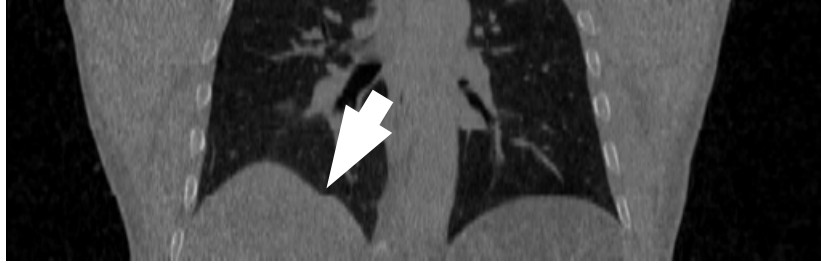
Example of artefact in gated cine CT that results from inter cycle variations in respiratory amplitude. A spatial discontinuity is seen on the superior edge of the liver.
